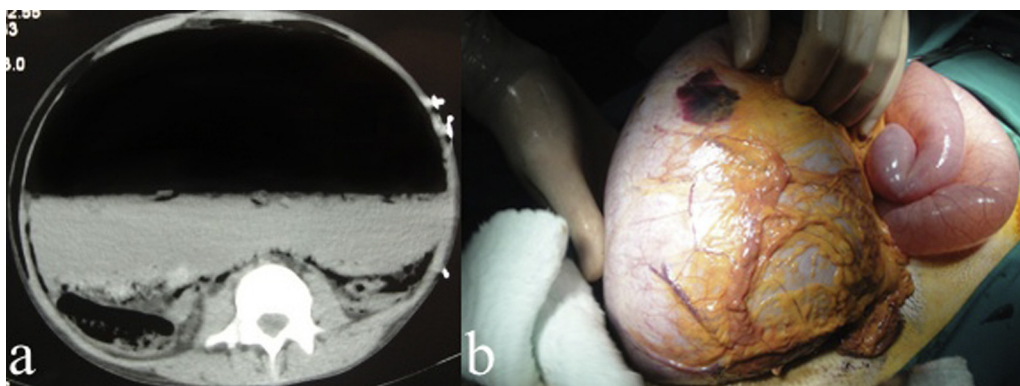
(a) Abdominal CT; intraabdominal free air and fluid with extensively enlarged stomach. (b) operative view; extensively enlarged stomach.
